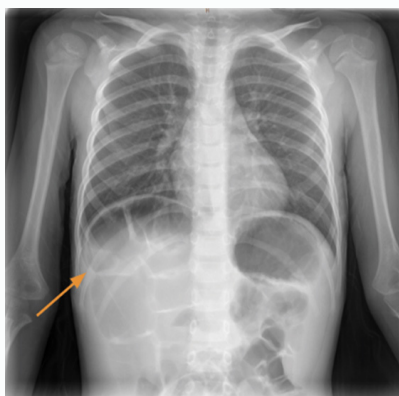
Chest and abdominal X-Ray from a patient that demonstrates colon anterior to liver (interposition).
